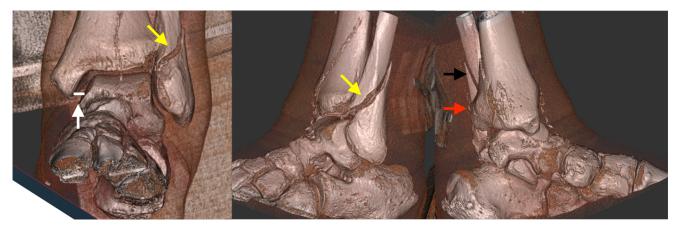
3D computed tomography scan of the left ankle in anterior view (preoperative). The yellow arrow points to the spiral fracture of the fibula, which was at the level of the syndesmosis, whether the fracture is displaced or not was not visible. The anterior view did not show any fracture of the tibia. The distance between the medial malleolus and medial talus seemed to be increased.
